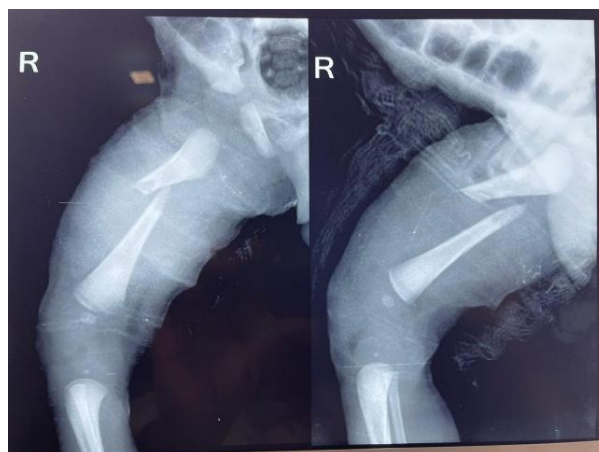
Xray of Neonate with Isolated femur fracture at presentation
